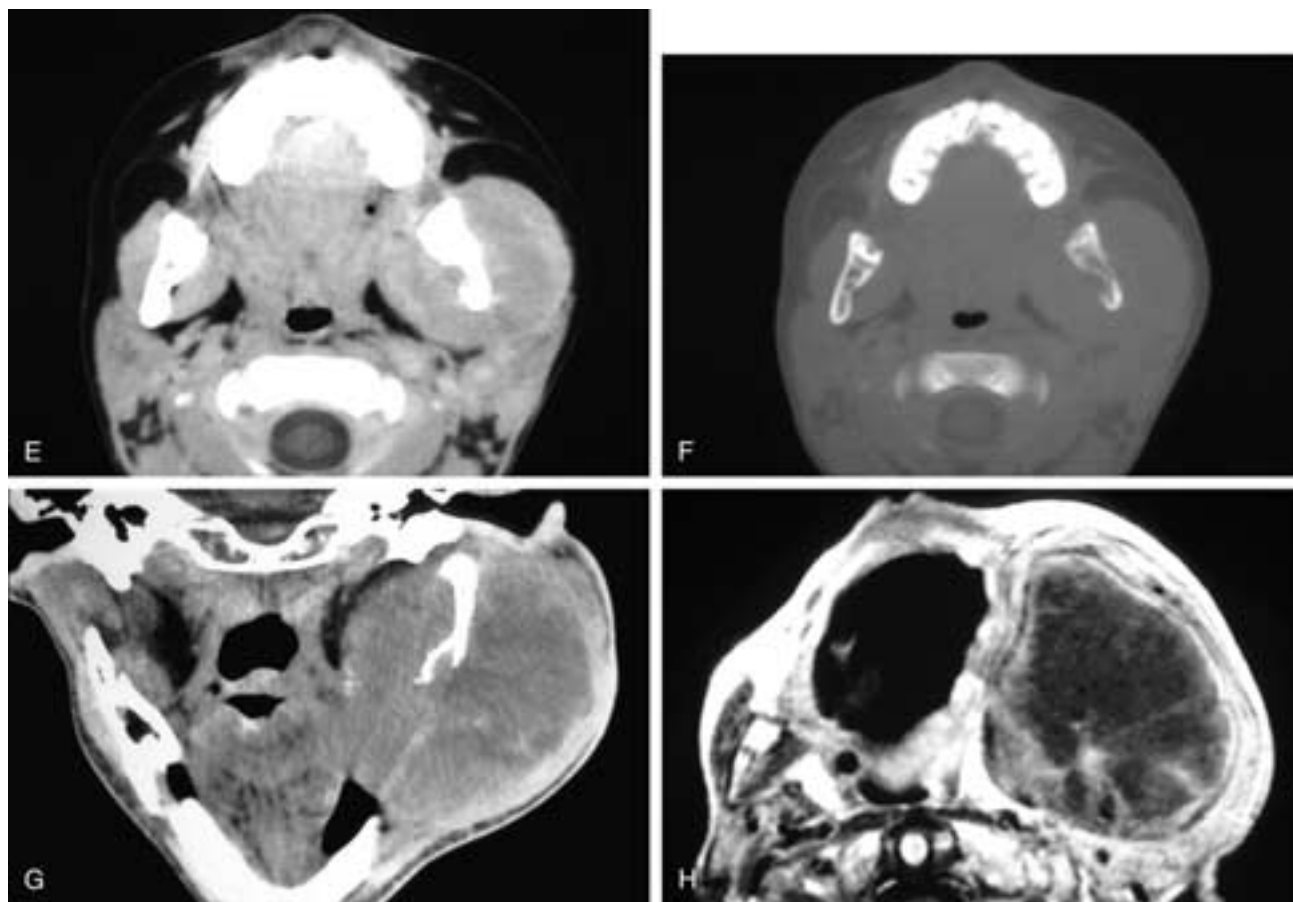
Continued.* Axial CT scans viewed at narrow soft-tissue window settings (E) and wide bone window settings (F) show a rhabdomyosarcoma in the left masticator space that has permeated the mandibular ramus but is contained by the masticator space fascia. Coronal CT scan (G) and axial T1-weighted MR image (H) show a large, destructive left masticator space mass. Much of the left mandible has been destroyed by this metastatic melanoma. However, the masticator space fascia contains the tumor, and there is no extension into the parapharyngeal space or the superficial soft tissues.
